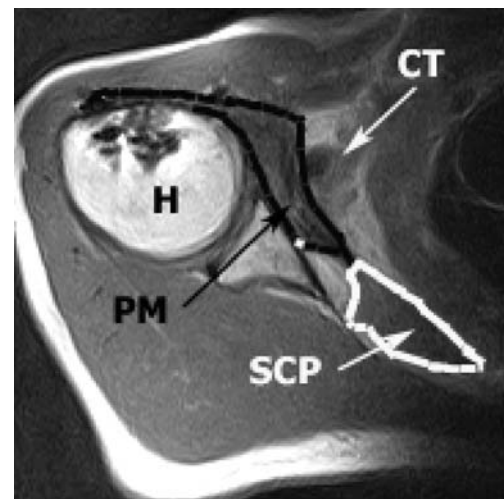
Postoperative MRI scan of the right shoulder after pectoralis major transfer. The subscapularis muscle (SCP) is retracted (borders highlighted with a *white line*). The pectoralis major (PM) (borders highlighted with a *black line*) runs under the conjoint tendon (CT) to the lesser tuberosity at the humerus (H). Note the metal artefacts in the humeral head due to the titanium suture anchors
